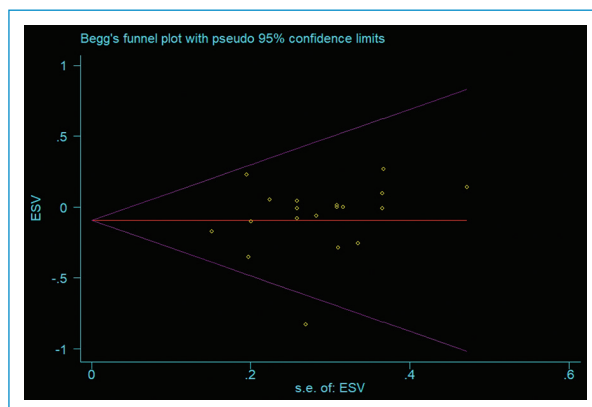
Funnel plot of publication bias for ESV (MRA vs. CTA), Begg's p 0.401.
